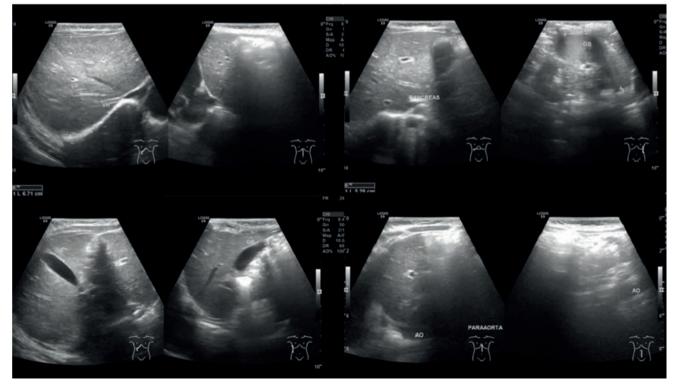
The abdominal ultrasound evaluation after treatment revealed normal
